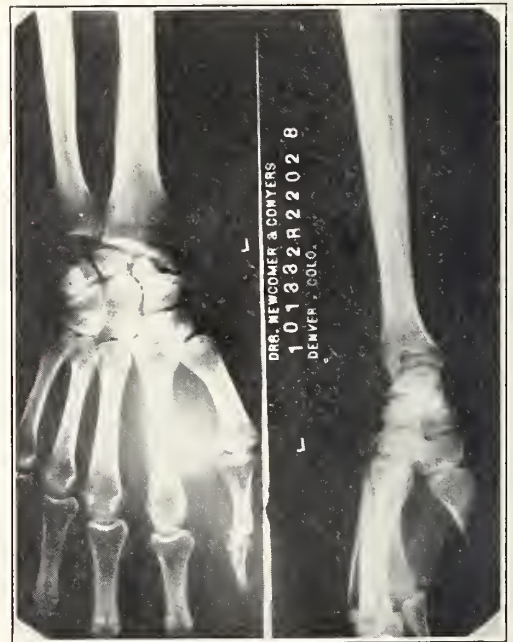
Roentgenogram showing an osteoporosis of the semilunar, associated with an old ununited fracture of the scaphoid.
